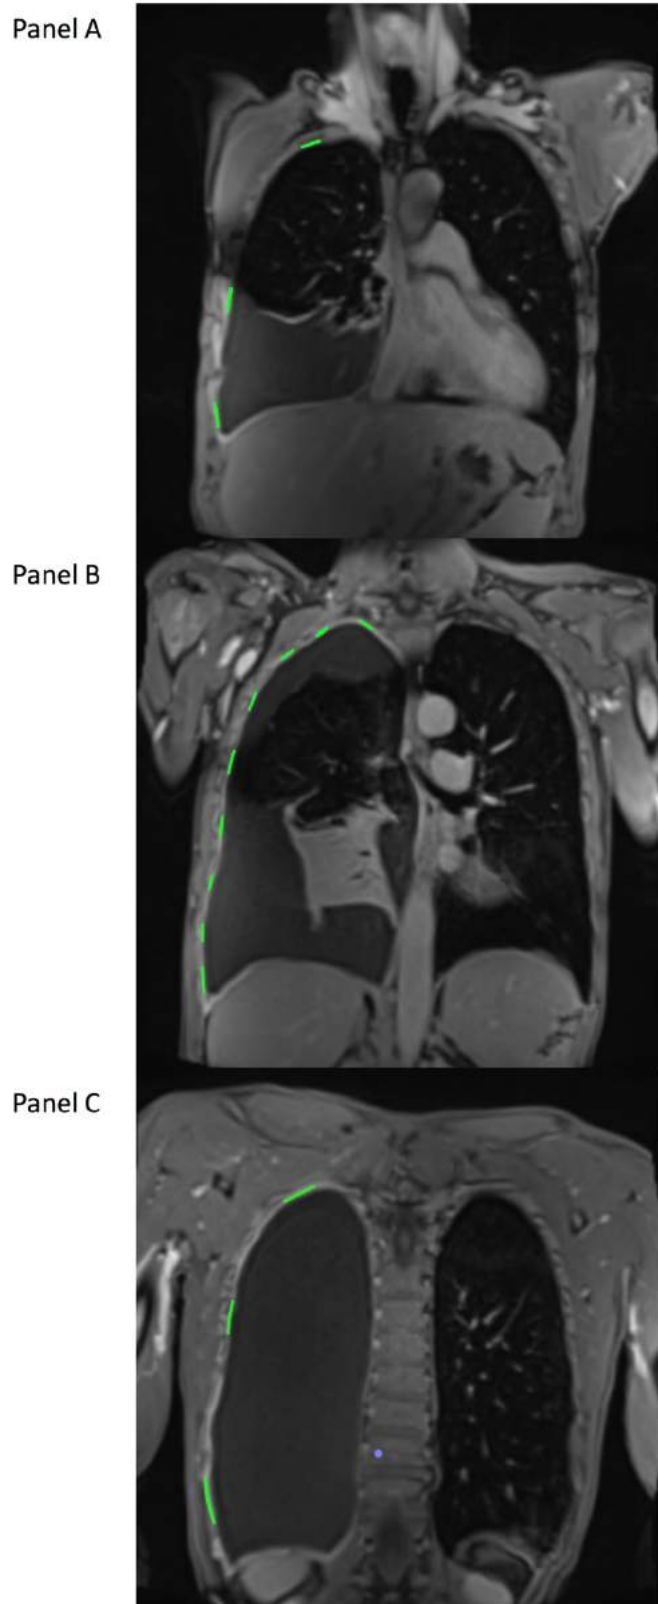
Example of ROI placed on representative pleura in the absence of macro-nodular disease at contrast-enhanced MRI
